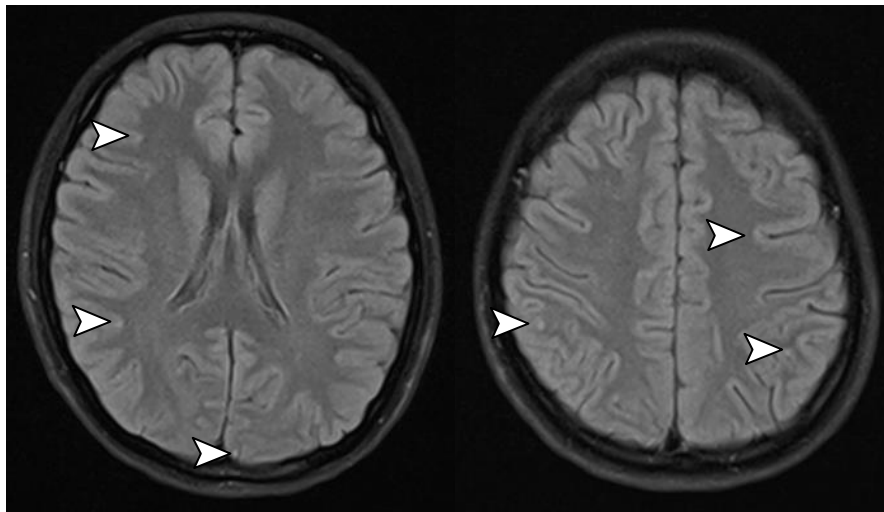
Magnetic resonance imaging (MRI) of the brain showing tiny foci of mild FLAIR hyperintensity at grey-white matter junction suggestive of early vasculitis changes (arrowheads).
